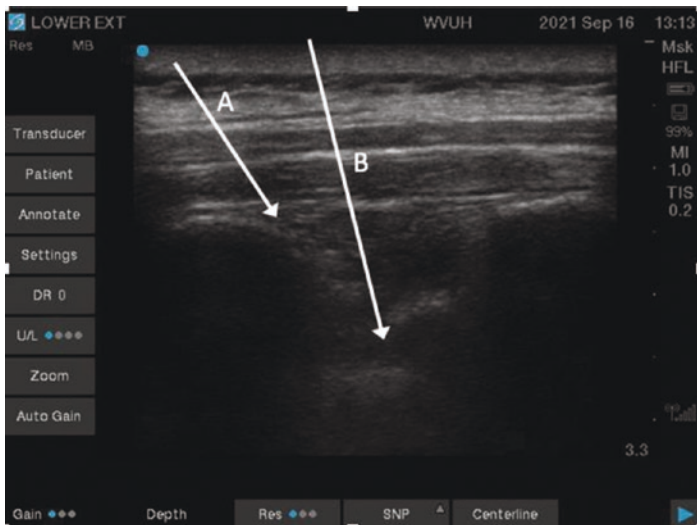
Ultrasound image for Erector Spinae plane (A) and Paravertebral (B)
